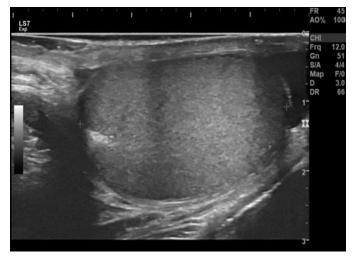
Ultrasound of the scrotum: Left testis appears normal. No evidence of focal lesions.
